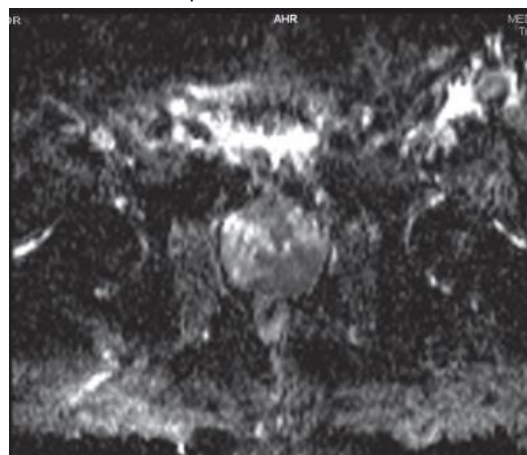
Axial DWI. Area of restriction of diffusion located inferior posterior on the left side.
